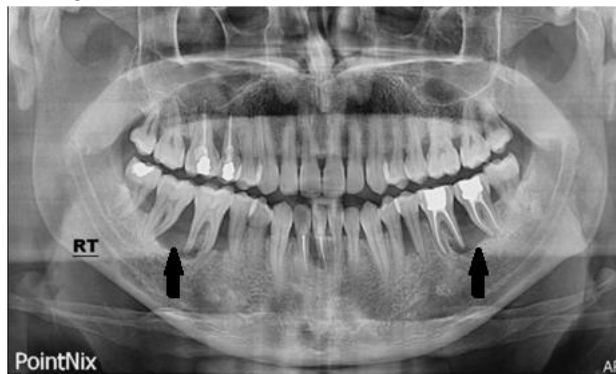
Intraoral panoramic radiograph. Arrows point to radiolucent lesions
